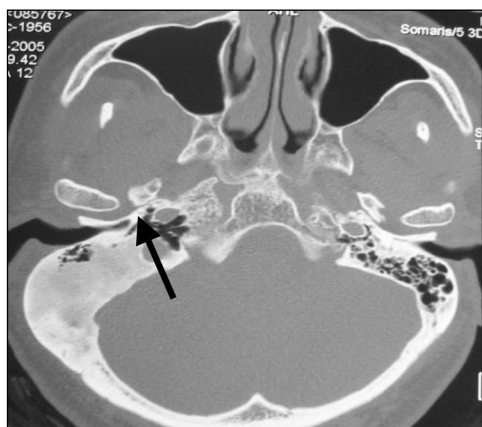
Axial CT demonstrating bony overgrowth involving the right temporal bone with sclerosis of all the mastoid air-cells. However the right external and middle ear cavities are spared as showed by the arrow. The left temporal bone appears grossly normal.
